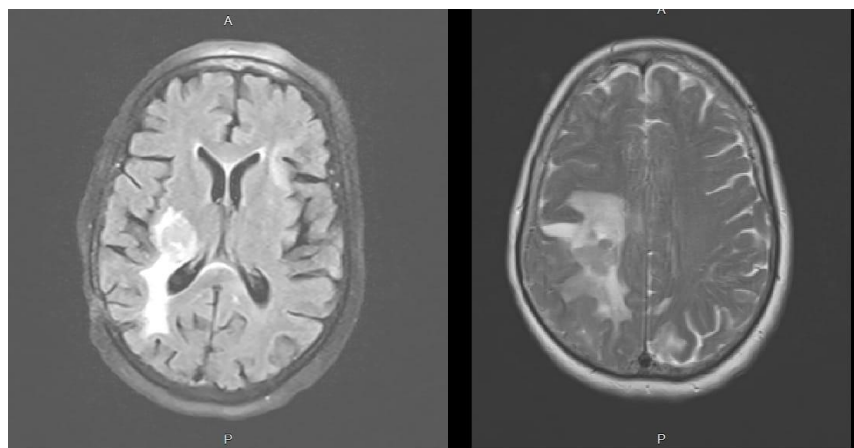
DWI and DWI in MRI, in the middle part of the right partial lobe, there is a solid, hyperintense, irregular diffusion.
